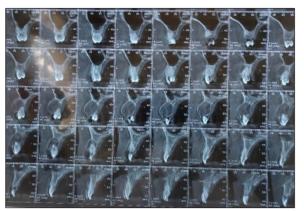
CBCT scan of the right maxilla showing a well-circumscribed, homogeneous radiolucent lesion estimated to measure 18 mm in height and 13 mm in mesiodistal width, located between the roots of teeth 13 and 14. Note the displacement of both teeth, buccal cortical plate expansion, and the detection of small peripheral foci of calcification within the lesion.
